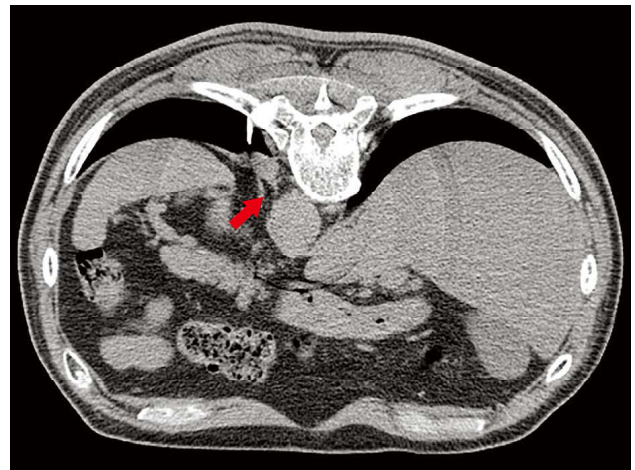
Chest CT in the CT-guided biopsy, showing a feeding vessel from the thoracic aorta.
